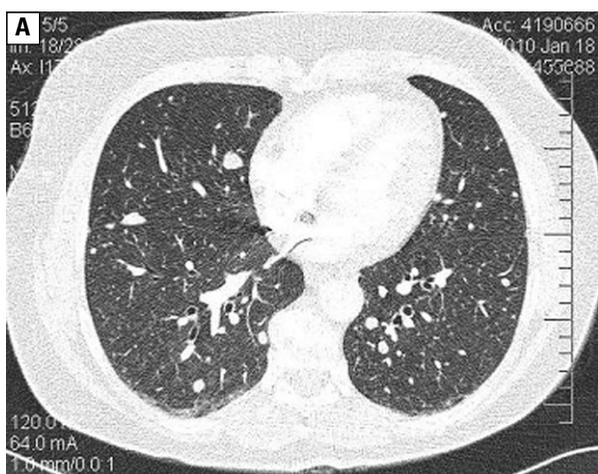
CT scan (lung and mediastinal window) multiple, bilateral well contrast-enhanced nodules
